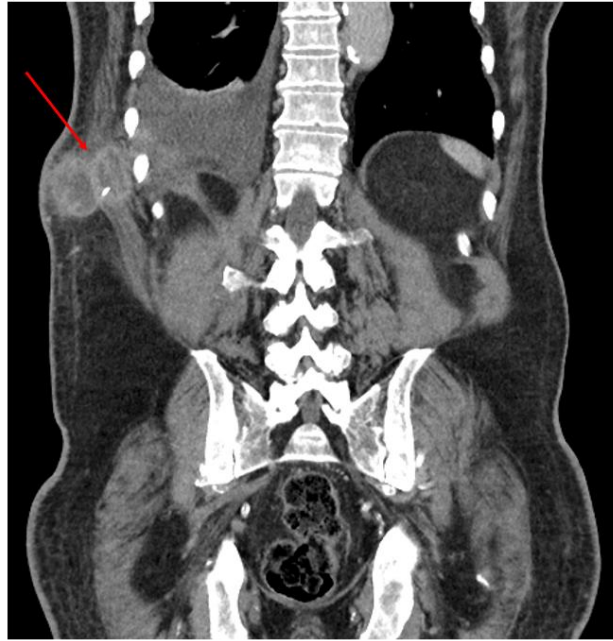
Coronal CT scan image showing a perihepatic abscess and a retained metallic clip necessitating through the right abdominal wall into the subcutaneous tissues [arrow]
